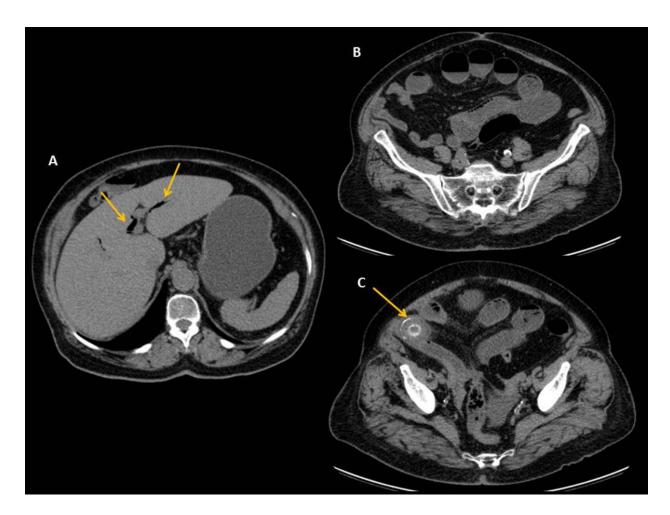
Gallstone ileus. CT scans show tubular areas of low attenuation in the biliary tree (arrows), corresponding to pneumobilia (A). Note the central location of the air, which does not extend to within 2 cm of the liver capsule. (B) Distended small intestine is observed with air-fluid levels (*). (C) A gallstone is observed at the terminal ileum (arrowhead) due to a cholecystoduodenal fistula. The presence of pneumobilia, dilated small intestine and the presence of a luminal calculus in the intestine characterize the Rigler triad.
